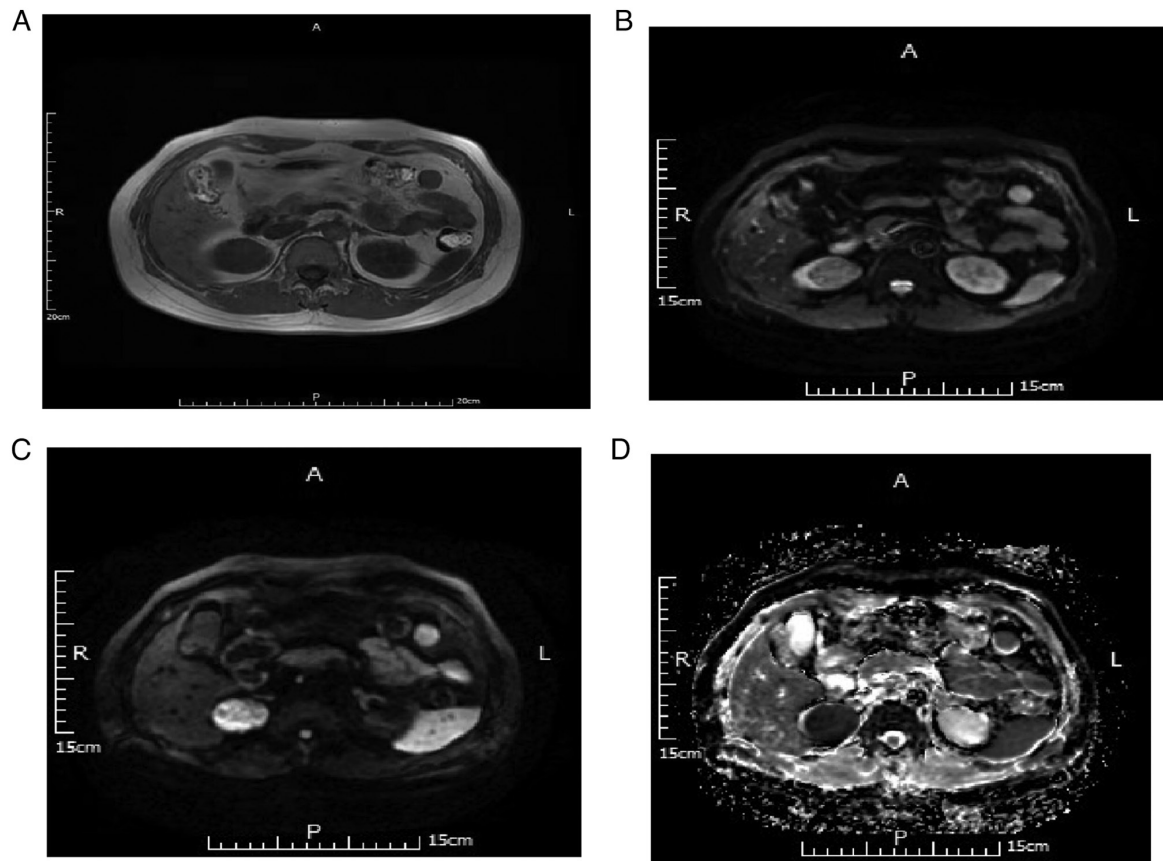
MRI scans of a 63-year-old male with pathologically confirmed renal papillary carcinoma of the right kidney. (A) T1WI, right renal tumor with low signal. (B) DWI B=50, right renal tumor with low signal. (C) DWI B=800, right renal tumor with high signal. (D) Apparent diffusion coefficient with low signal. DWI, diffusion-weighted imaging.
